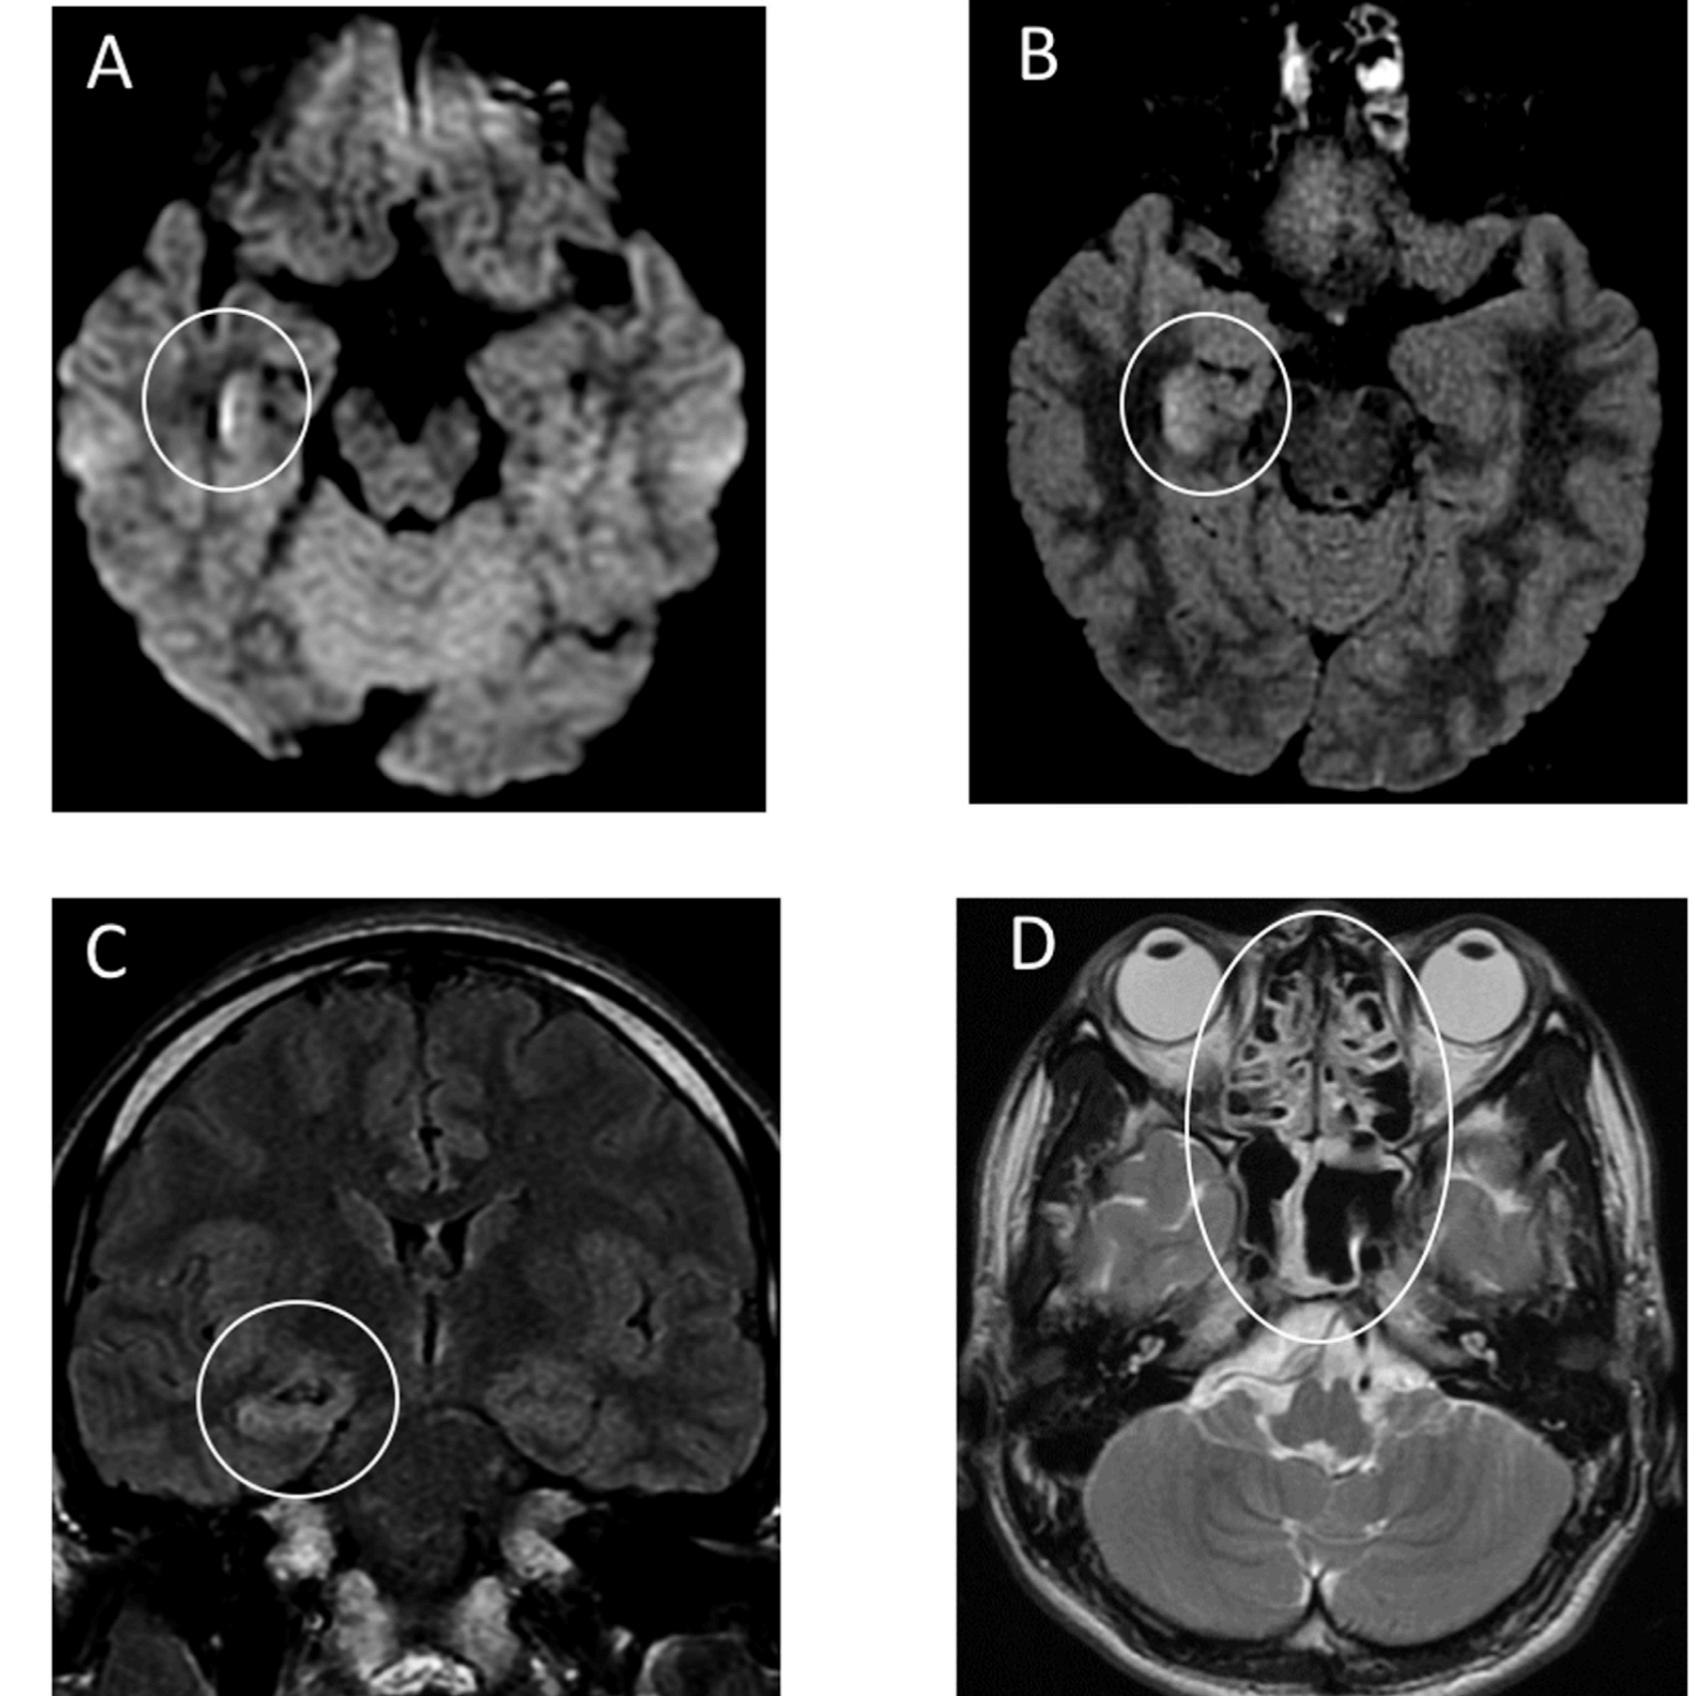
Brain MRI performed 20 hours after admission.
